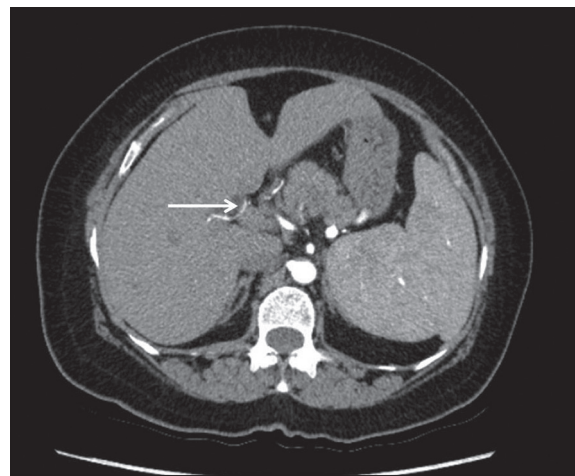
A 56-year-old woman, a voluntary kidney donor, underwent contrast-enhanced computed tomography axial sections of the abdomen which shows an extrahepatic branch from right hepatic artery supplying segment 4 as indicated by the arrow.
